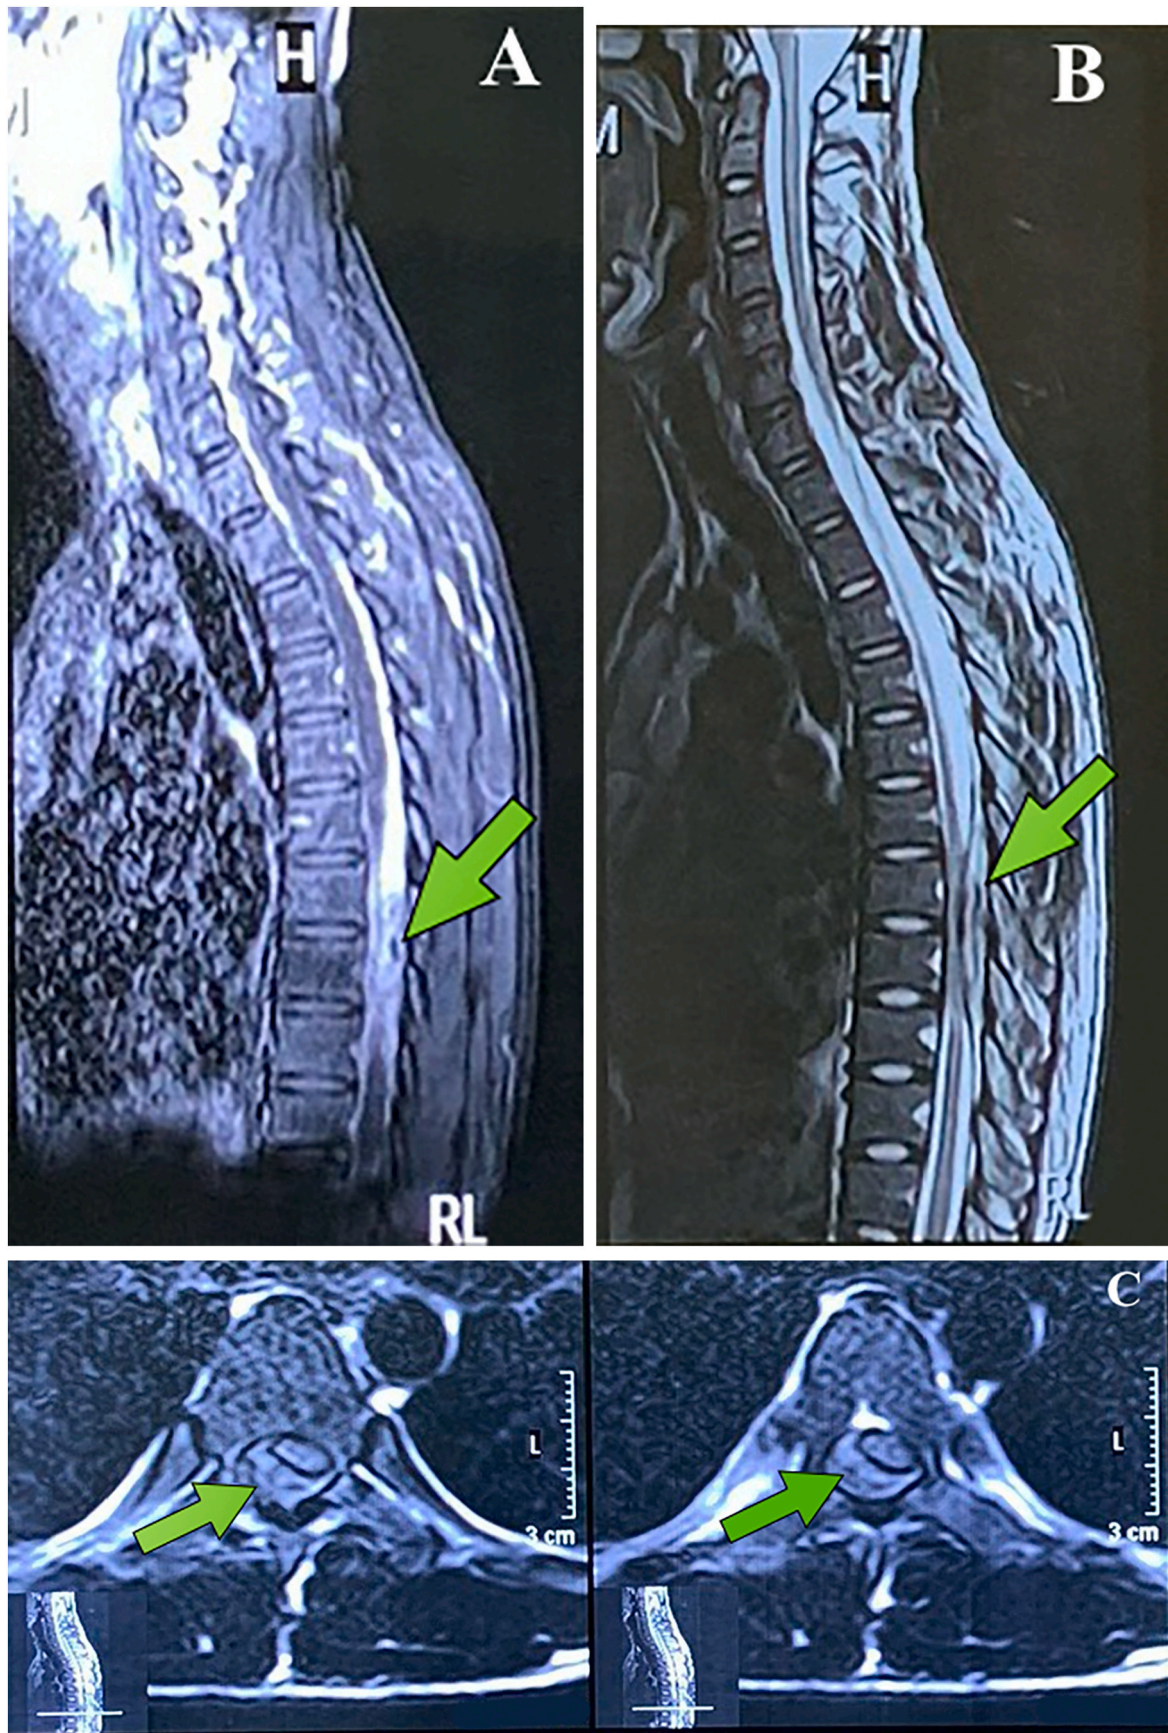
Magnetic resonance imaging of the spine (MRI) showed the mass (green arrow) was a heterogeneous hyperintense on T2W, STIR, and isointense on T1W and enhanced contrast vividly.
